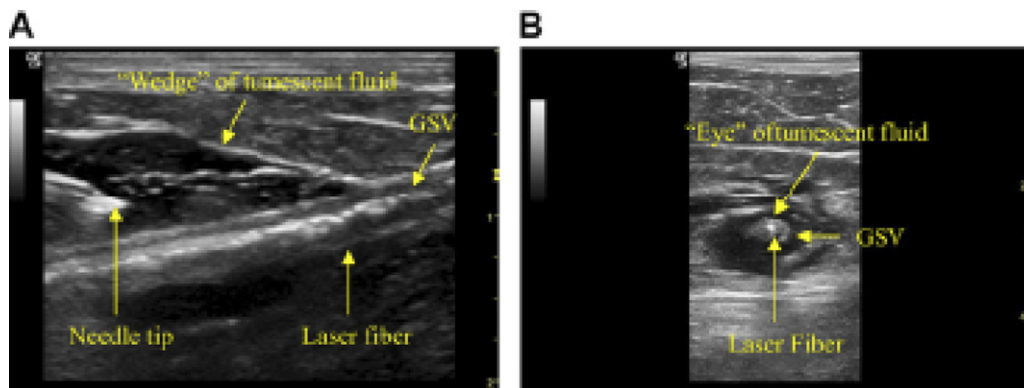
Ultrasound makes tumescent anesthesia possible. (A) Longitudinal and (B) cross-sectional ultrasound view. It is a key factor in safe and effective thermal ablation results. GSV, great saphenous vein. Reprinted from Gibson KD, Ferris BL, Pepper D: Endovenous laser treatment of varicose veins. Surg Clin N Am 87:1253-1265, 2007,³⁹ with permission.
